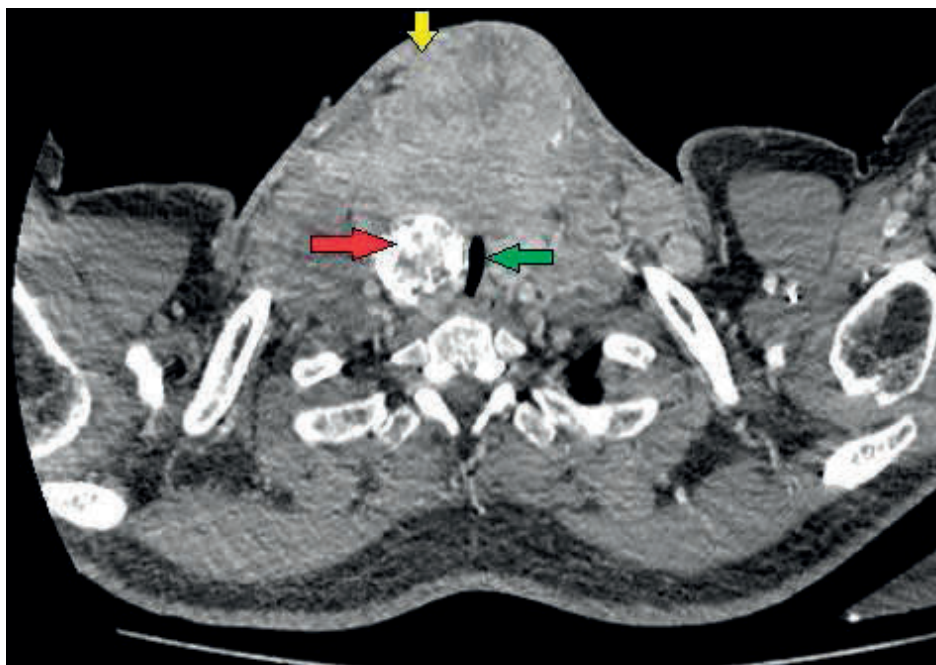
Axial view of contrasted CT scan of the neck showed a heterogenous large neck lesion with poor demarcation plane with underlying subcutaneous fat tissue (yellow arrow) and narrowing of airway (green arrow). There was calcification at right side of trachea (red arrow).
